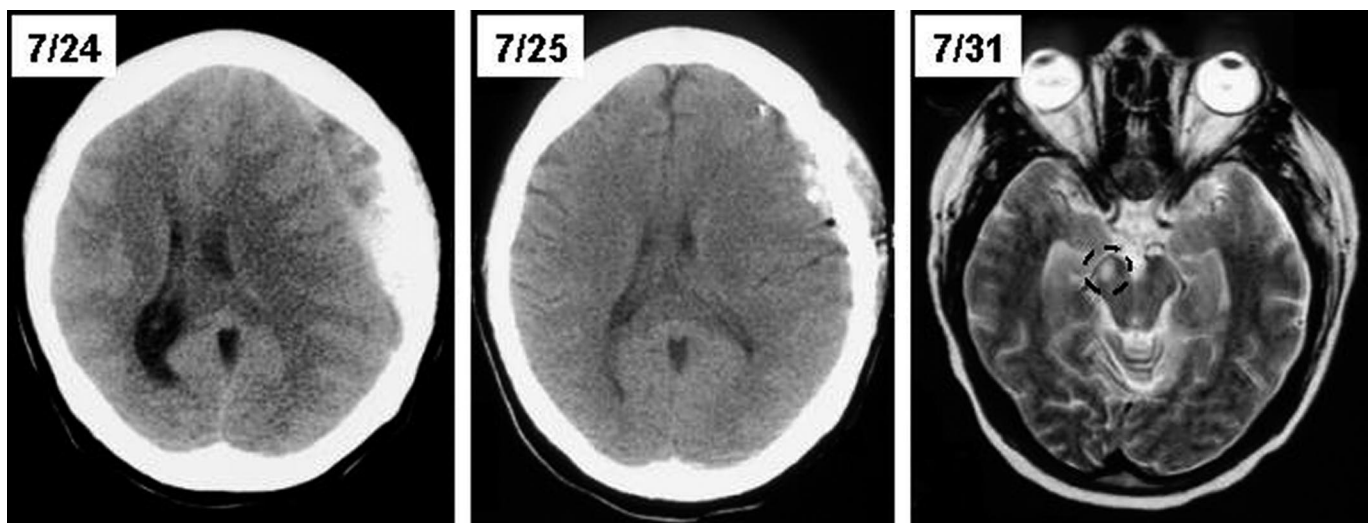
CT brain scan showed a left subdural hematoma with 1.5 cm midline shift (panel 7/24). After emergency platelet transfusion, the subdural hematoma was evacuated. Brain CT the next day showed resolution of the shift (panel 7/25). Brain MRI a week later showed a cerebral peduncle lesion in the T2-weighted sequence (panel 7/31). There was no history of head trauma.
